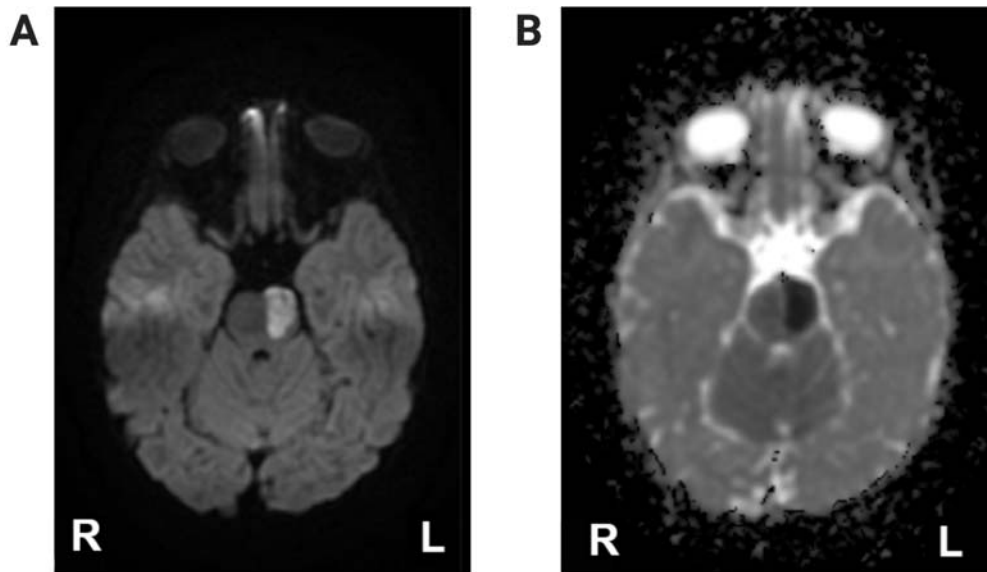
Brain imaging of patient. (A) Magnetic resonance diffusion-weighted imaging sequence showing left pontine stroke; (B) magnetic resonance imaging apparent diffusion coefficient sequence.
